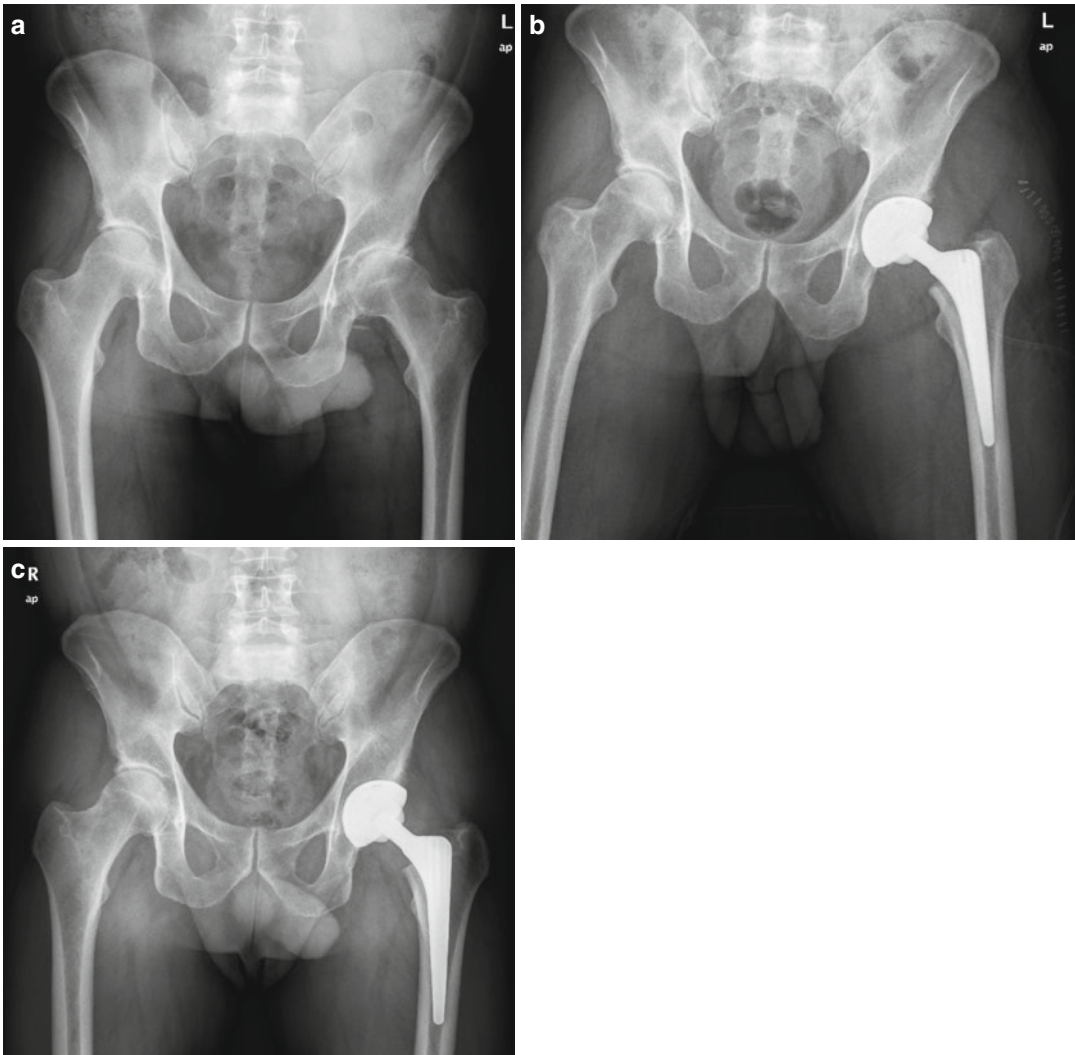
(a) Preoperative radiograph of a 49-year-old patient with hip hemophiliac arthropathy. An osteopenic acetabulum and a funnel-shaped femoral canal can be observed. (b) Radiograph of the same patient at the first postoperative week with a cementless press-fit cup and a
